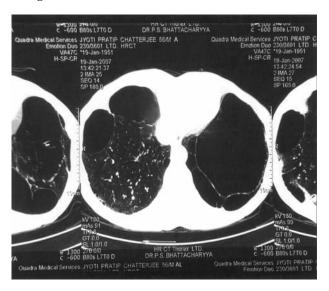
Pre-procedure HRCT showing a large bulla in the left lower lobe.
